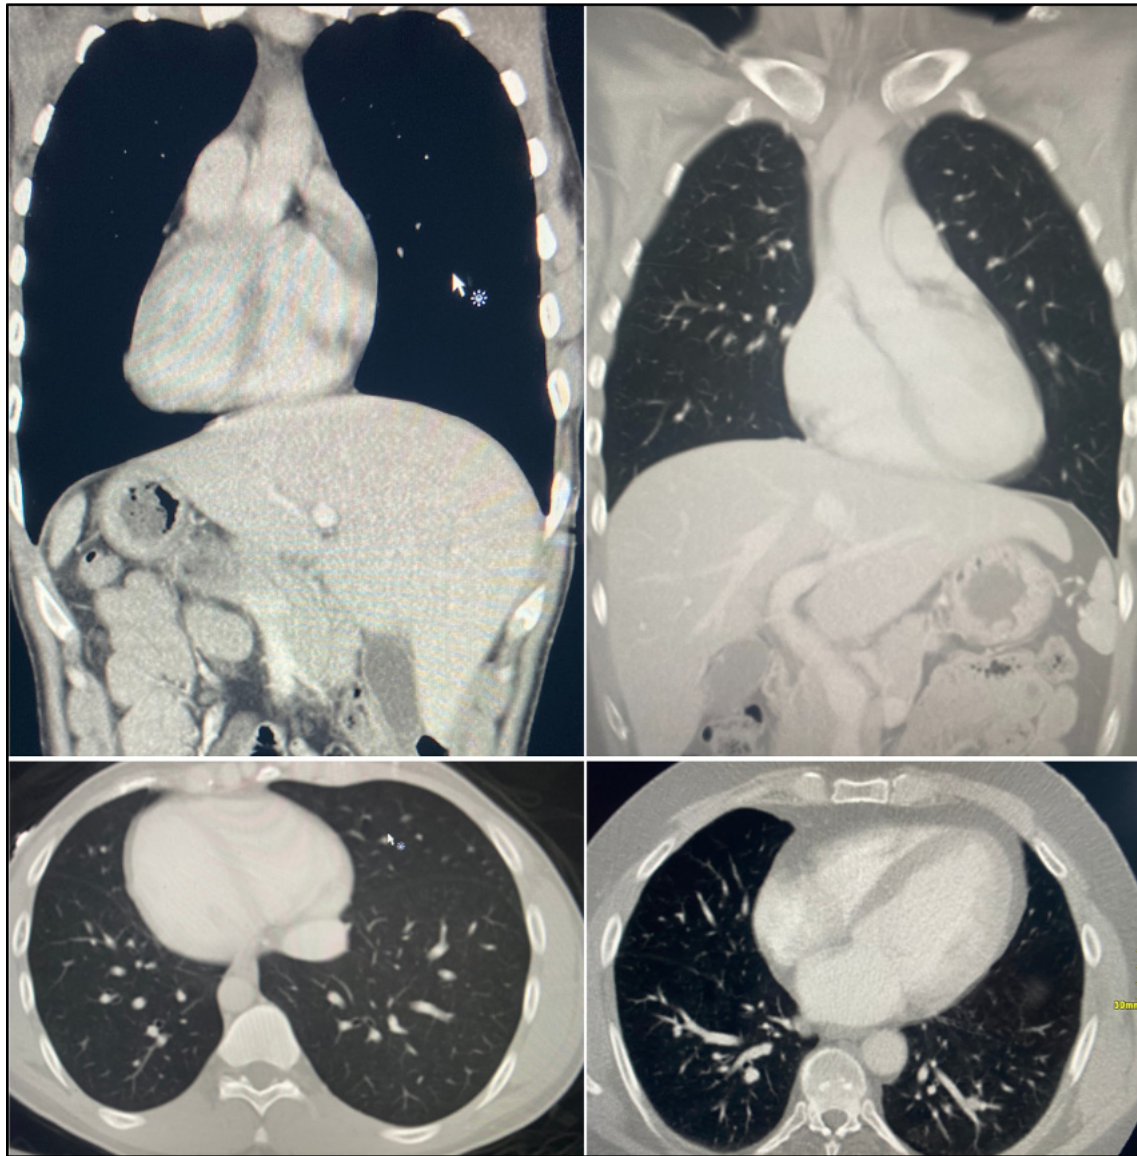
Coronal and axial CT images of situs inversus. Left upper and lower images show mirror-image reversal of the heart and aorta resulting in dextrocardia and right-sided aortic descent. In the abdomen the liver is in the left upper quadrant where the spleen usually resides. Right upper and lower coronal and axial images show normal situs of chest and abdominal viscera.
